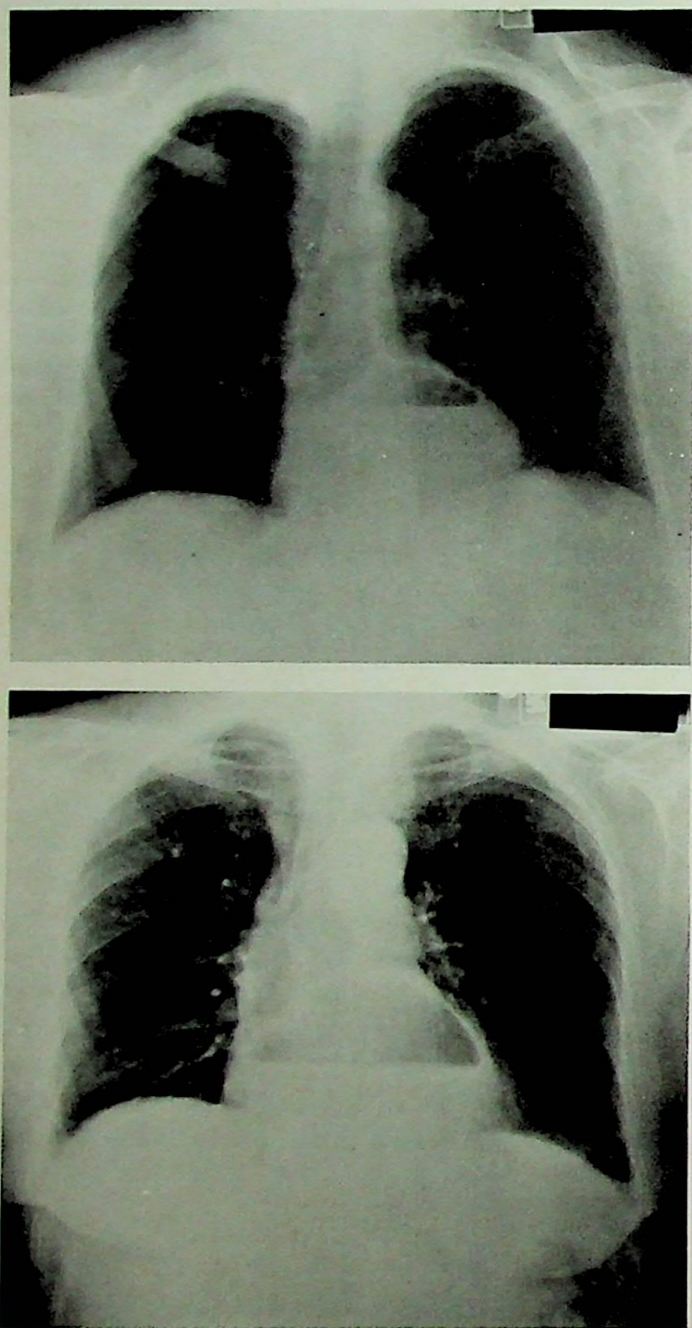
Chest roentgenograms showing diaphragmatic hernias in two patients with iron deficiency anemia.
